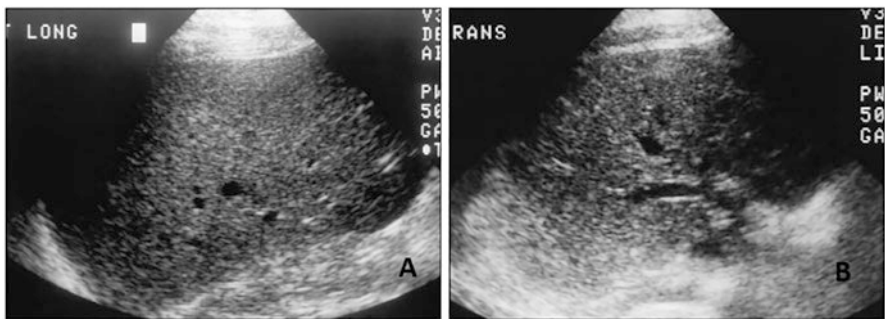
Ultrasonogram showing (a) fibrotic liver with regions of pinhead echoes, moderate inflammation, mild steatosis, and fibrosis. (b) mild-severe swelling, absence of fibrosis, and steatosis with presence of nodular pattern. (Reprinted with permissions from [42])
